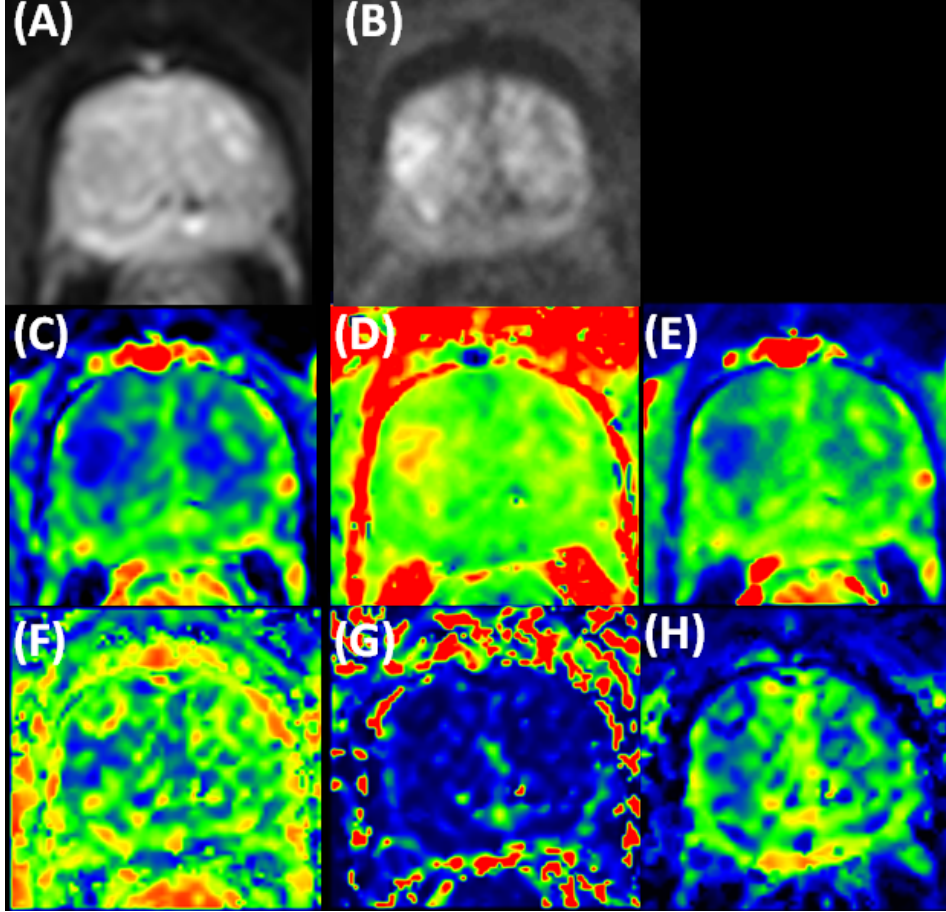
DWI image of prostate, and parameter maps of three DWI models. Original DWI signal samples are: (A)  $B_0$ -weighted image ( $b=0$  ms/mm<sup>2</sup>), and (B)  $B_{2000}$ -weighted image ( $b=2000$  ms/mm<sup>2</sup>). Sample images for parameter maps calculated with DWI models are kurtosis  $ADC$  (C) and  $K$  (D), monoexponential  $ADC$  (E) and biexponential  $f_{biexp}$  (F),  $D_{fast}$  (G) and  $D_{slow}$  (H). The images show a tumour on the left side of the central zone of the prostate (bright spot in  $B_{2000}$  image). The parameter maps allow us to make measurements in the tissue for tumour detection and characterization.
